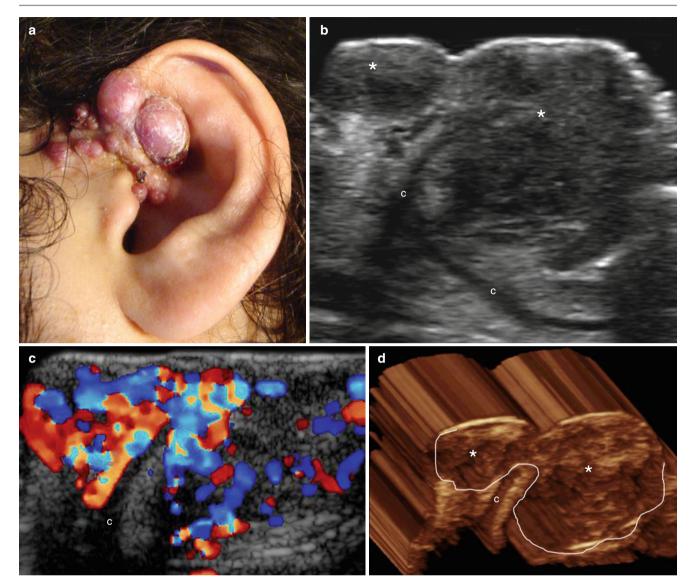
(a–d) Epithelioid hemangioma (angiolymphoid hyperplasia with eosinophilia). (a) Clinical lesion shows multiple erythematous bumps that affect the left ear pinna and pre-auricular region. (b). Grey scale ultrasound (transverse view) demonstrates hypoechoic and confluent nodules and pseudonodules (*) that involve the cutaneous
